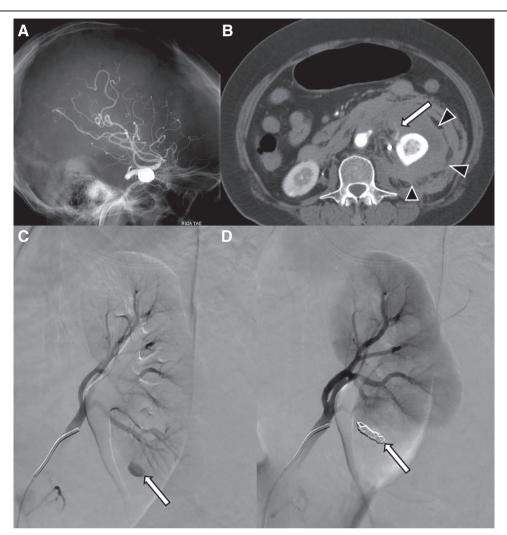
Case 3. A 65-year-old female received stent-assisted embolization of the aneurysm at right supra-clinoid ICA (A). Pt. developed hypovolemic shock in the postanesthesia care unit. Contrast-enhanced abdominal CT showed a left RSH (B, arrowheads) with an active contrast extravasation from left lower renal pole kidney (B, arrow). Left renal angiogram disclosed a bleeder from a lower interlobular artery (C, arrow). Embolization of the bleeder was done by placement of fiber coils in the left inferior segmental artery (D, arrow). CT = computed tomography; ICA = internal carotid artery; RSH = renal subcapsular hematomas.
